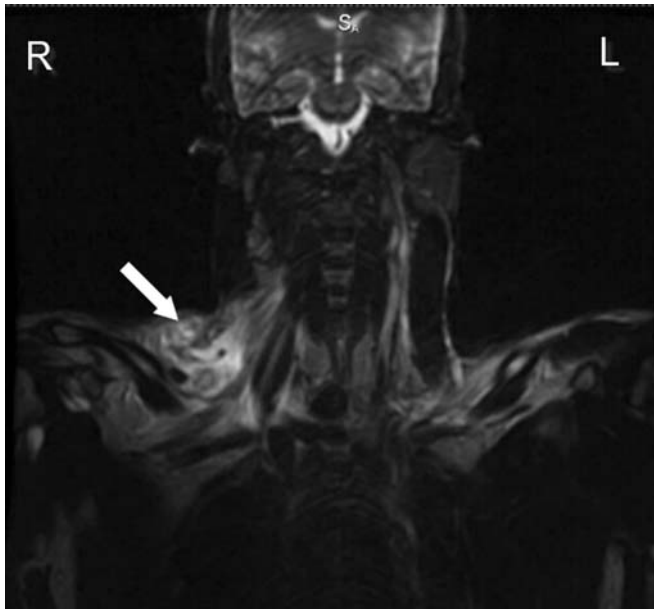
Right supraclavicular hematoma. Low-resolution coronal T2, fat-suppressed MR image displays asymmetry of soft tissues with right-sided hematoma (arrow)
